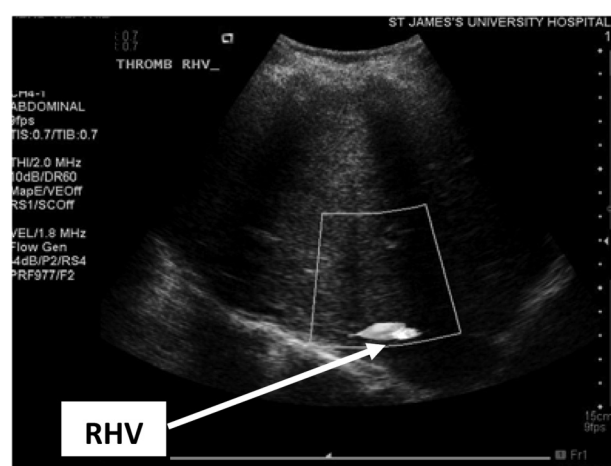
Transverse colour Doppler sonogram showing lack of flow within the right hepatic vein (RHV) consistent with occlusion.
